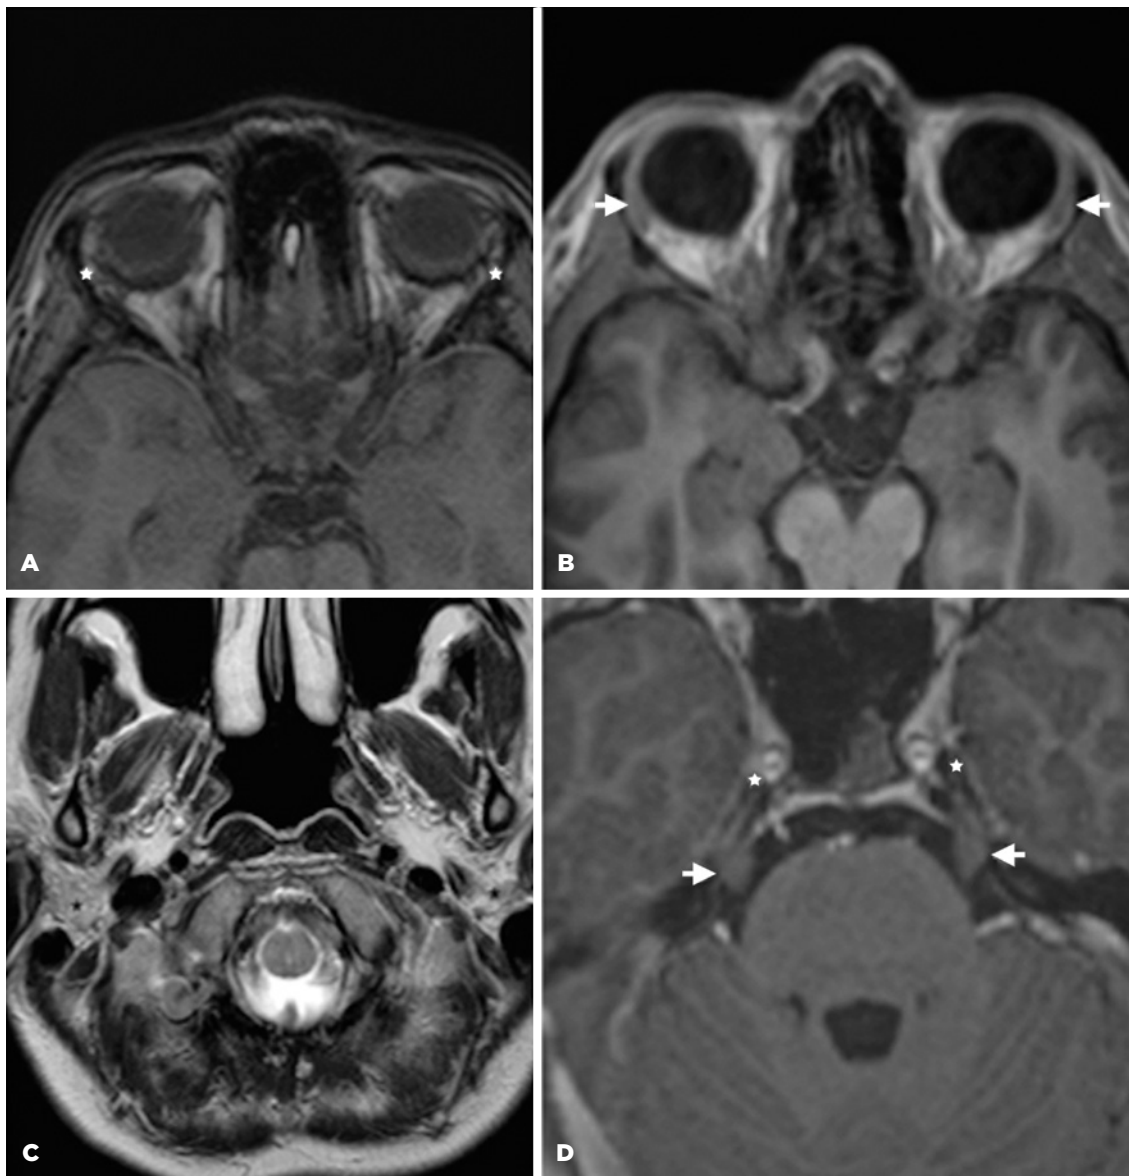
Case 1. A. Axial T1-weighted magnetic resonance (MR) image, of the upper level of orbits shows the absence of the lacrimal glands (asterisk). B. Axial T1-weighted image, at the same level, in a normal subject (for comparison) shows the usual pattern of the lacrimal glands (white arrows). C. Axial T2-weighted image shows a normal appearance of the parotid glands of this sequence, with high signal (asterisk). The asymmetry between the right and left sides is due to a slight rotation in the transverse plane. D. T1 axial oblique plane shows the cisternal portion of the trigeminal nerve (arrows) and Meckel's cave (asterisks).
